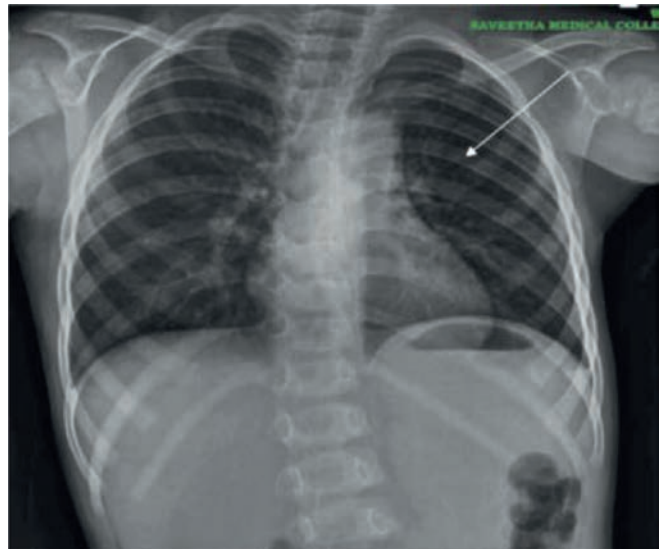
Chest radiograph posteroanterior view showing unilateral (left) hyper lucency of chest with absent pectoralis major muscle as indicated by the white arrow
